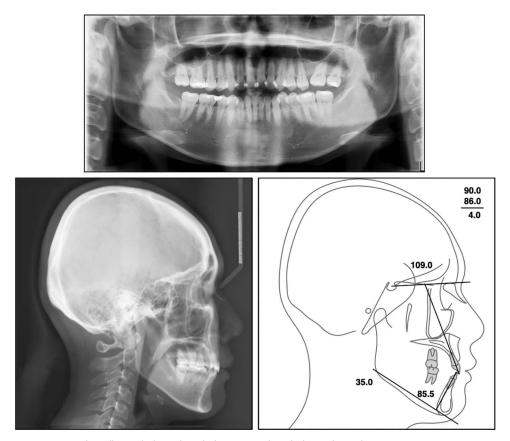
Posttreatment panoramic radiograph, lateral cephalogram, and cephalometric tracing.
